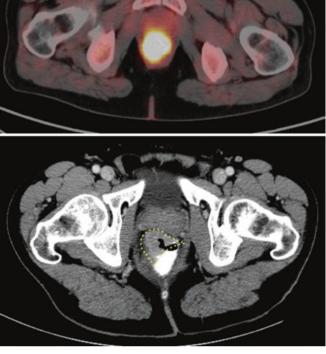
PET/CT. Molecular imaging using fluorodeoxyglucose (FDG) PET/CT for the assessment of tumor response to nCRT. Baseline images show obvious FDG uptake in the primary tumor (a, PET and CT images fused with FDG uptake [top] and CT thickening of the anterior
